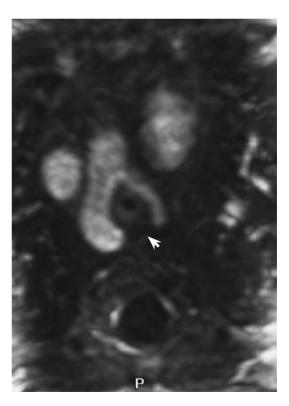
Double aortic arch. MRI with contrast medium. The dominant right aortic arch and smaller left arch encircle the airway and the esophagus. The posterior limb of the vascular ring is atretic (*arrowhead*)
